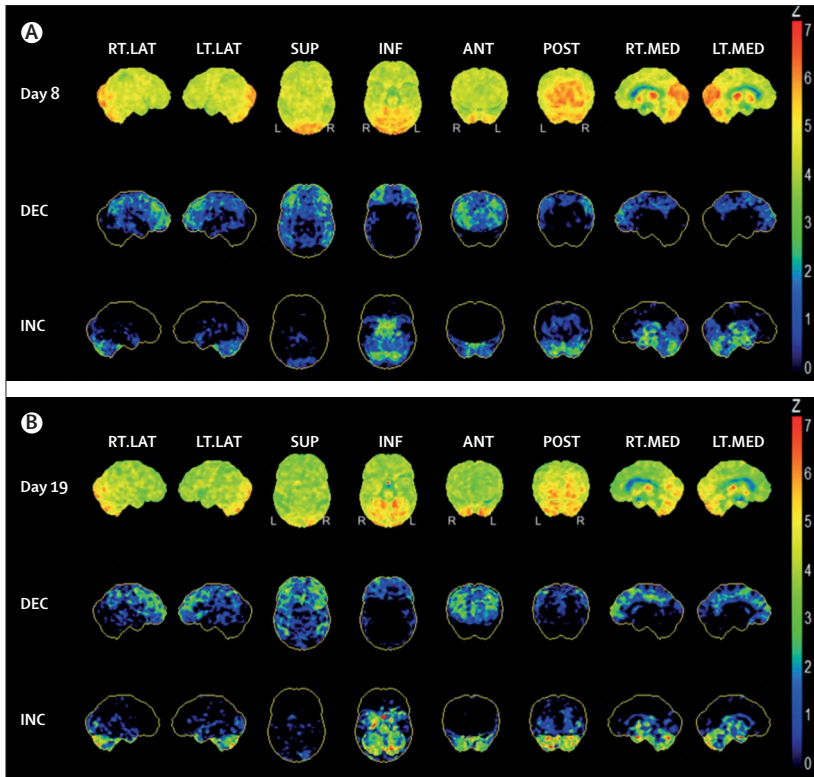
^{18}F -fluorodeoxyglucose PET/CT changes in Borna disease virus 1 encephalitis
